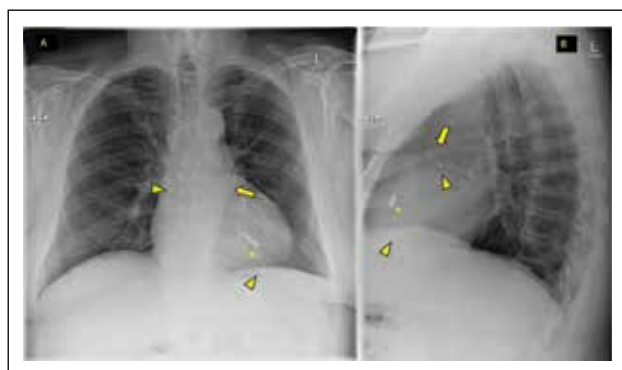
Frontal (A) and lateral (B) chest radiographs showing lead-less pacemaker in situ (asterisk). Note the presence of the LAA appendage closure device (arrow) and retained RA and RV pacemaker lead tips (arrowhead) as well. (Image courtesy: Marianne Cossens: Radiopedia)
